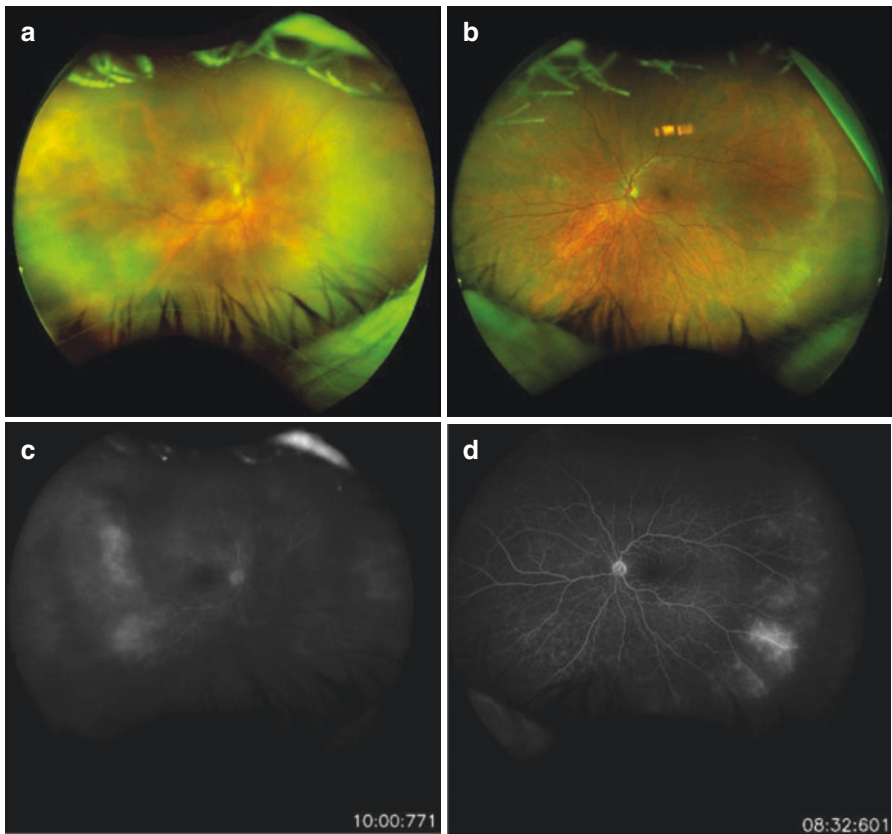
A 66-year-old Caucasian woman who presented with floaters for several months, initially treated with topical, subtenon, and oral steroids with no improvement. Laboratory evaluation and MRI of the brain and orbits were unremarkable. Visual acuity was 20/25 in each eye. Widefield fundus photos revealed diffuse vitreous cell and haze in the right eye (a), mild tortuosity of retinal vessels, and no chorioretinal lesions or disc elevation (a, b). Late frames of widefield fluorescein angiogram revealed peripheral vascular leakage in both eyes (c, d). Given high suspicion for PVRL, diagnostic vitrectomy was performed in the right eye. Flow cytometry and cytology were positive for a diffuse large B-cell lymphoma
